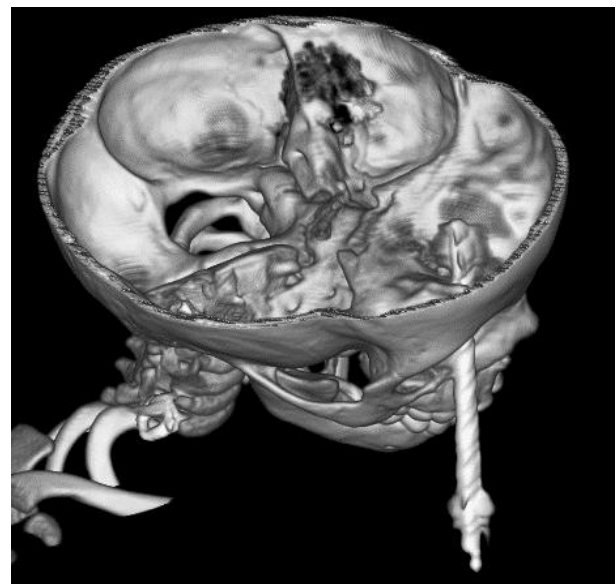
A 3-D CT scan revealed the penetrating injury in the anterior cranial fossa.
